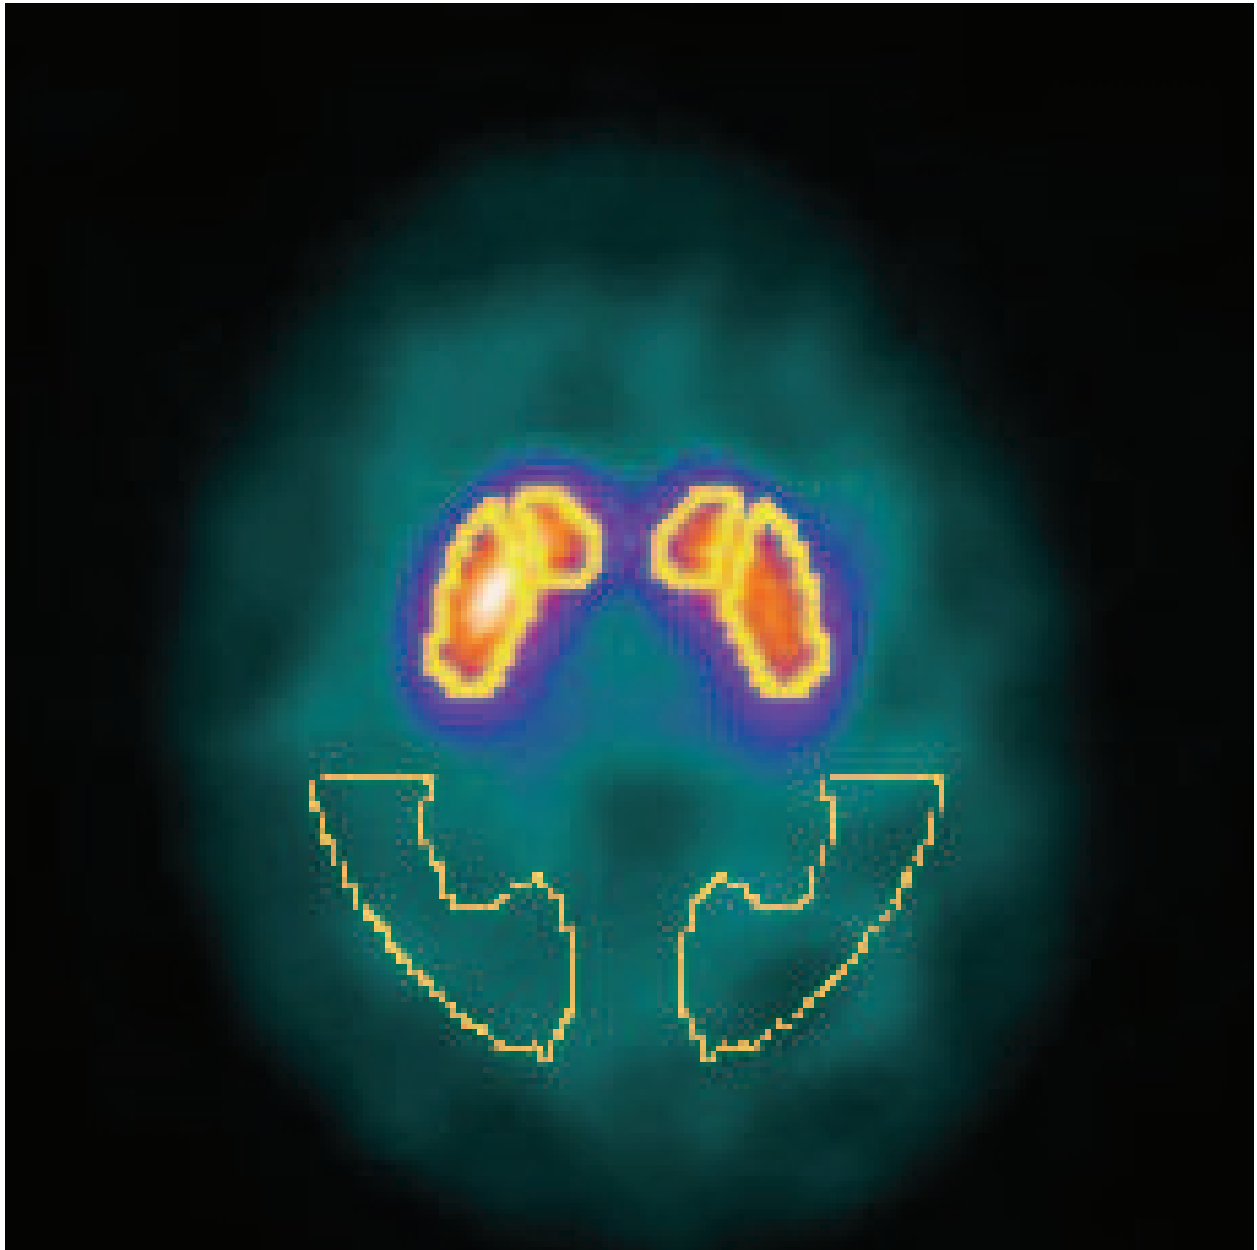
FP-CIT SPECT in a patient with PD of the tremor dominant type. The striatal FP-CIT uptake is reduced bilaterally.
